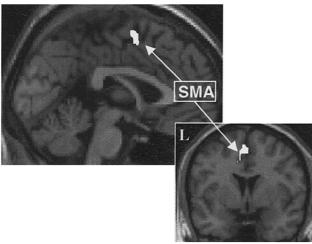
Brain regions significantly more activated during long delay trials (VLL) than short delay trials (VSS), presented on a standar-dised high-resolution MRI image (L=left).
